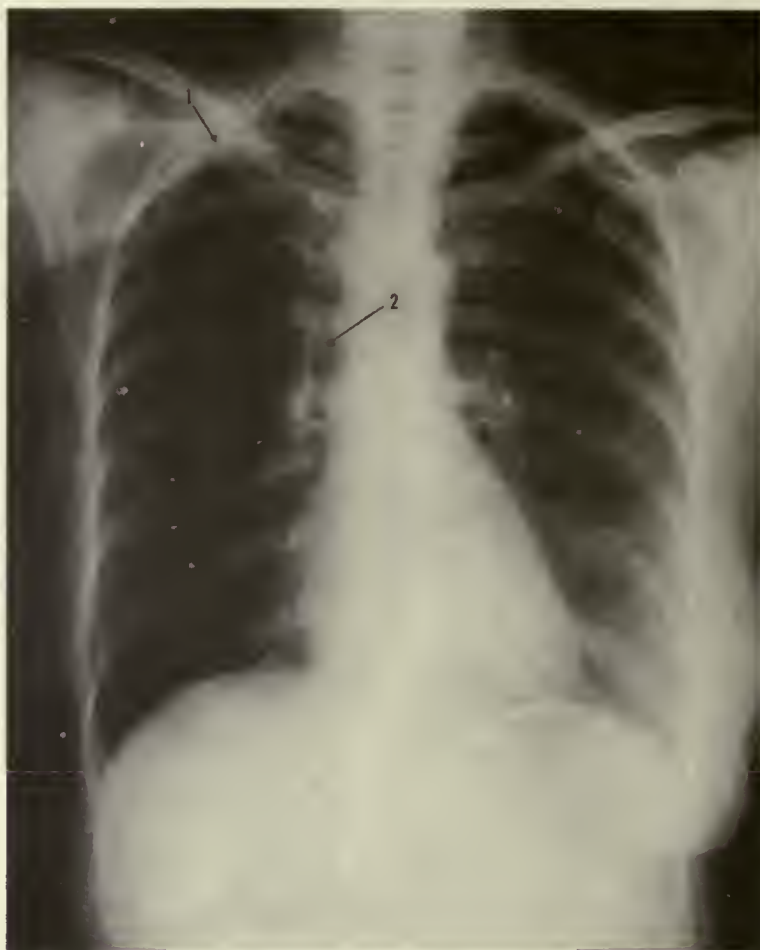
Postirradiation fibrosis in right lung (case 1). Film was made two years after course of X-ray therapy. Note right pleurodiaphragmatic adhesion and densities (1) in right infraclavicular area where dose was 5100 r and (2) above right hilum where dose was 2500 to 3500 r.
